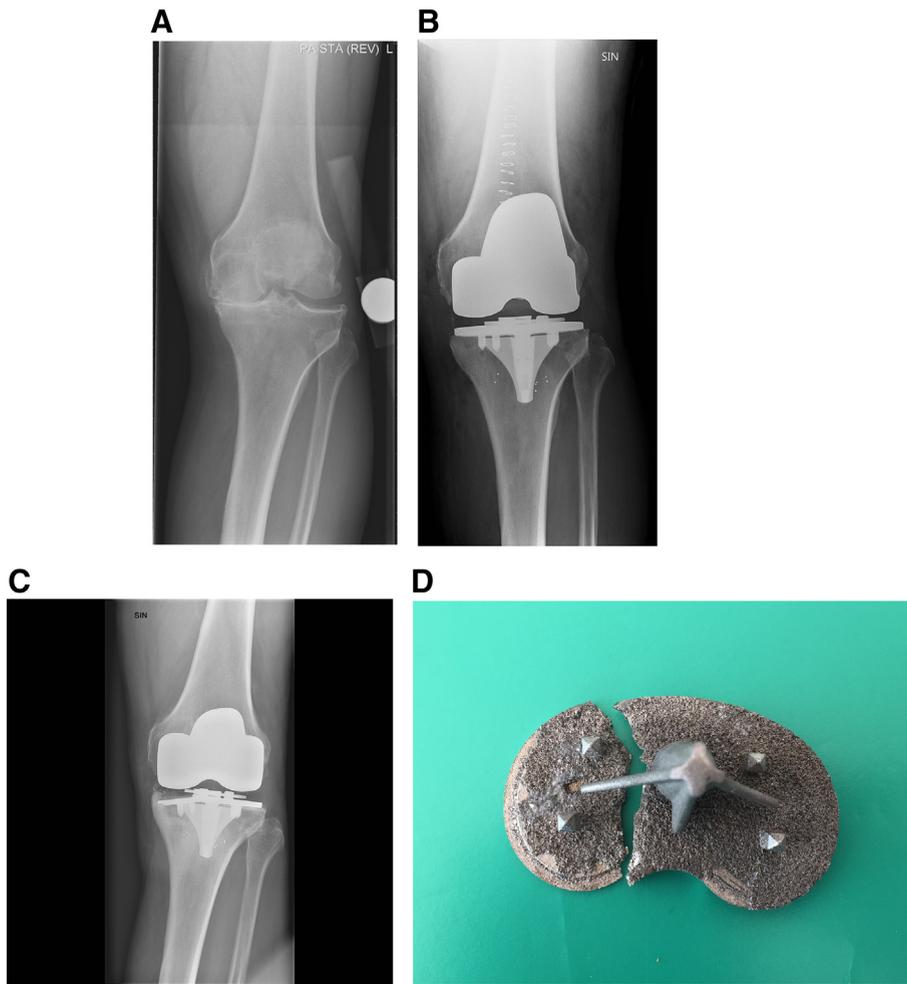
Case 3: Antero-posterior radiograph of the left knee, (A) preoperative, (B) postoperative, (C) 23 months after primary surgery, and (D) picture of retrieved tibia component with fracture of the metallic baseplate. Note that the Regenerex coating has separated from the tibial tray on the medial edge.
